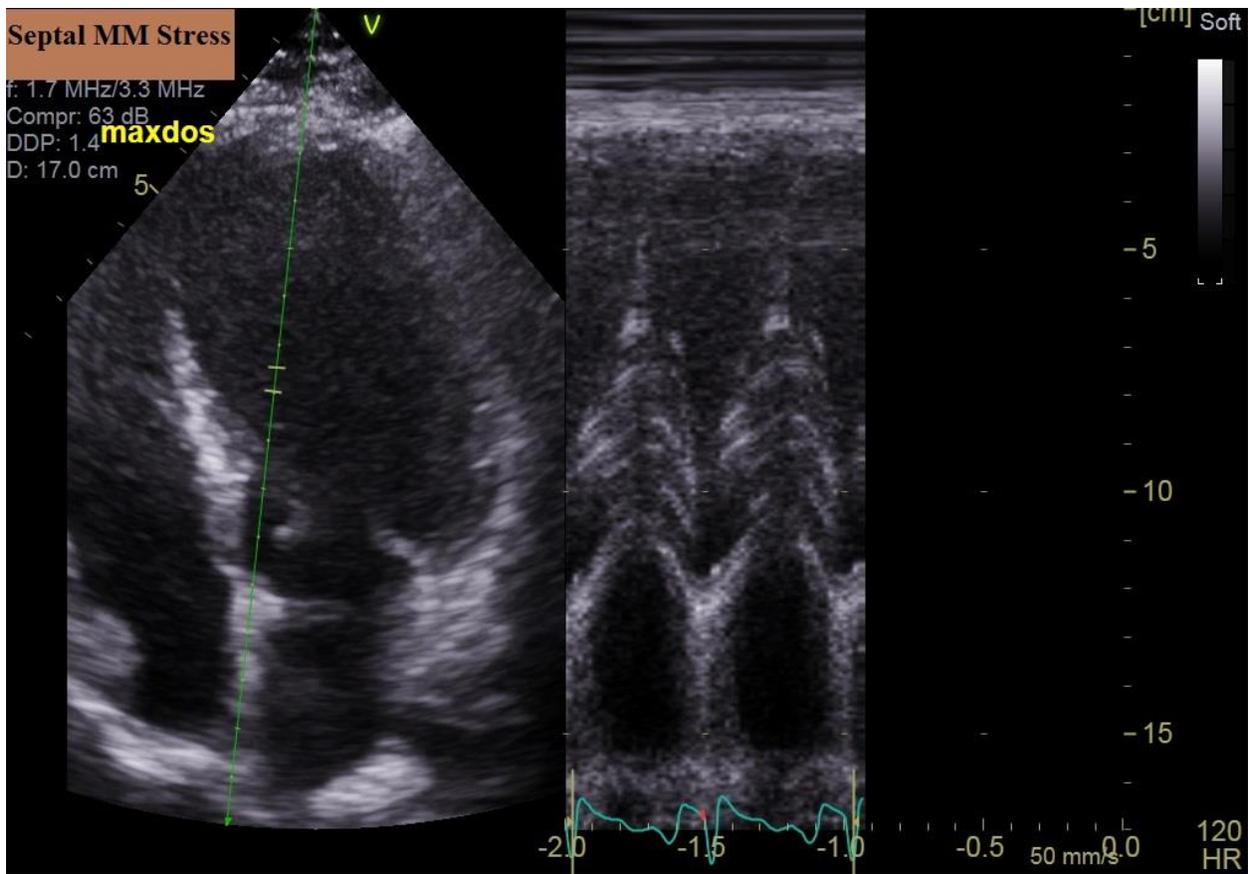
Trans-thoracic echocardiography, Septal M-mode at peak stress.
